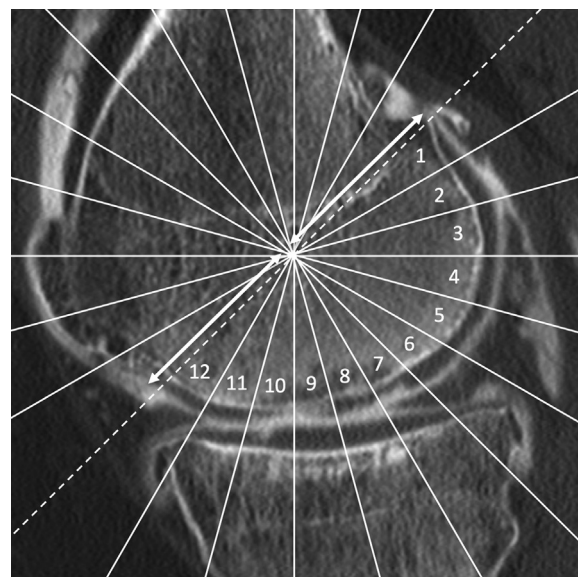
Midsagittal reformat of CT arthrogram of a medial knee compartment showing anteroposterior segmentation of femorotibial cartilage. A grid with 24 radial segments of 15° each was pasted on each sagittal reformat. The grid was panned so that 1/the -45° line (dashed line) would intersect the most posterior aspect of the distal femoral physal line and 2/the center of the grid would project halfway between the two intersections of this -45° line and the condylar cartilage (arrows of equal length in Fig. 1). On this slide, 12 cartilage segments, as indicated by the numbers, were analyzed by each of the five readers.
